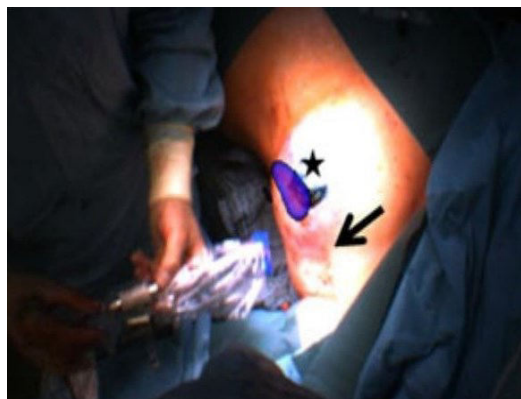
Postoperative Free hand SPECT image with no remaining activity; injection site is marked with Black star [16]
